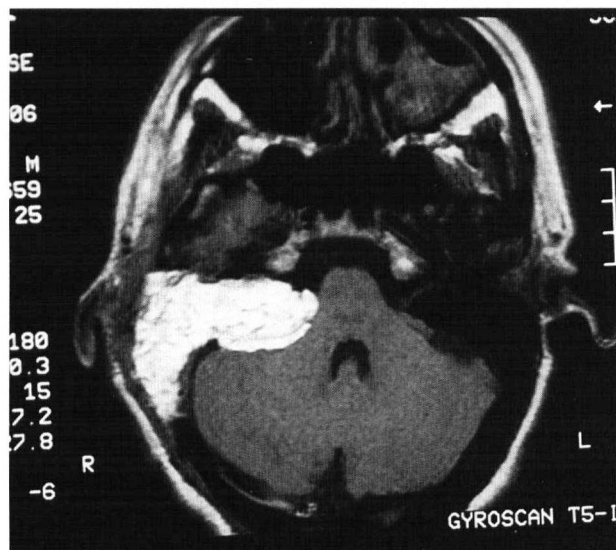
A magnetic resonance imaging test performed 3 days after removal of a vestibular schwannoma through the enlarged translabyrinthine approach. Note the medial ends of the fat strips located inside the cerebellopontine angle, filling the space previously occupied by the tumor.
